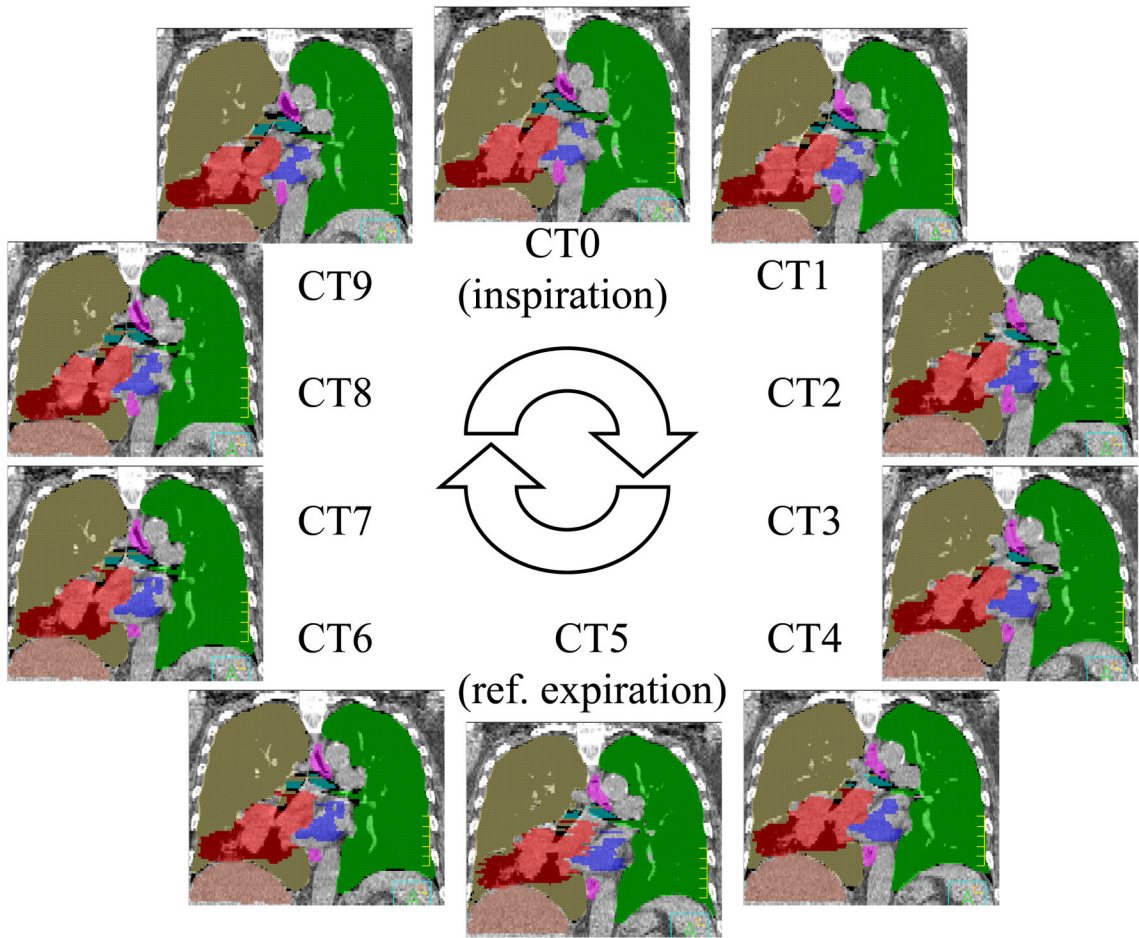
4D CT images for a lung case. A breathing cycle was divided into 10 equal-time phases. The reference contours were drawn on phase CT5, which is estimated to be the end expiration phase. The contours were then transformed to the rest phases using auto-contouring algorithm.
